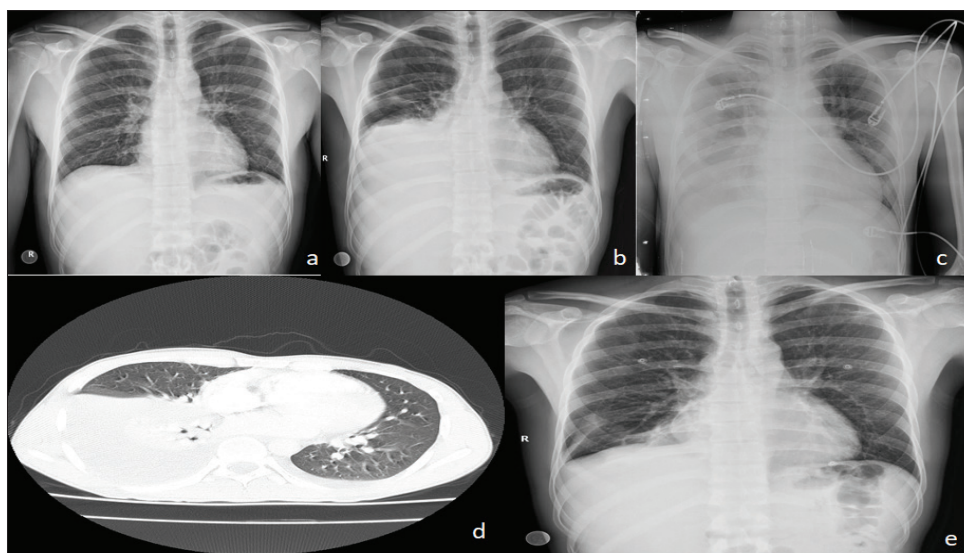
The follow-up radiological findings of a 28-year-old male who was survival; (a) Admission chest X-ray graphy. (b) Follow-up, treatment 2nd day (under antiviral treatment). (c) Follow-up, treatment 5th day (antiviral + blood product replacement therapy). (d) Follow-up, treatment 2nd-day computed thorax tomography. (e) Treatment result 10th day chest X-ray
